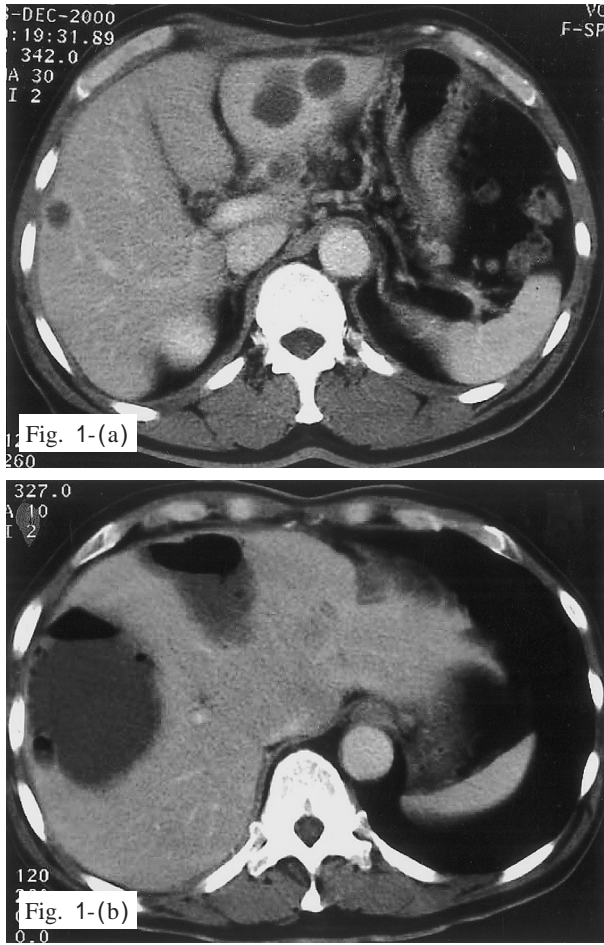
(a) Computed tomography shows multiple low-density areas (1~3 cm diameter in the both lobes of the liver. (b) Computed tomography shows abscess formation in the liver (a month after MCT).
